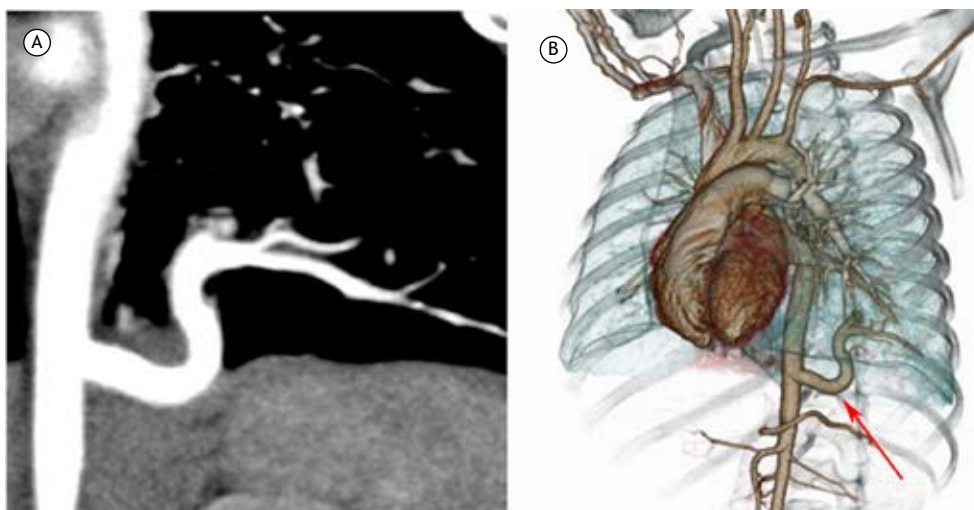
Anomalous systemic arterial supply to normal lung. In A, CT angiography shows an anomalous vessel originating directly from the aorta and heading to the left lower lobe. In B, three-dimensional reconstruction shows the anomalous artery (red arrow) and normal venous drainage of the left lung. In addition, the regional bronchial tree (not shown) was normal.
